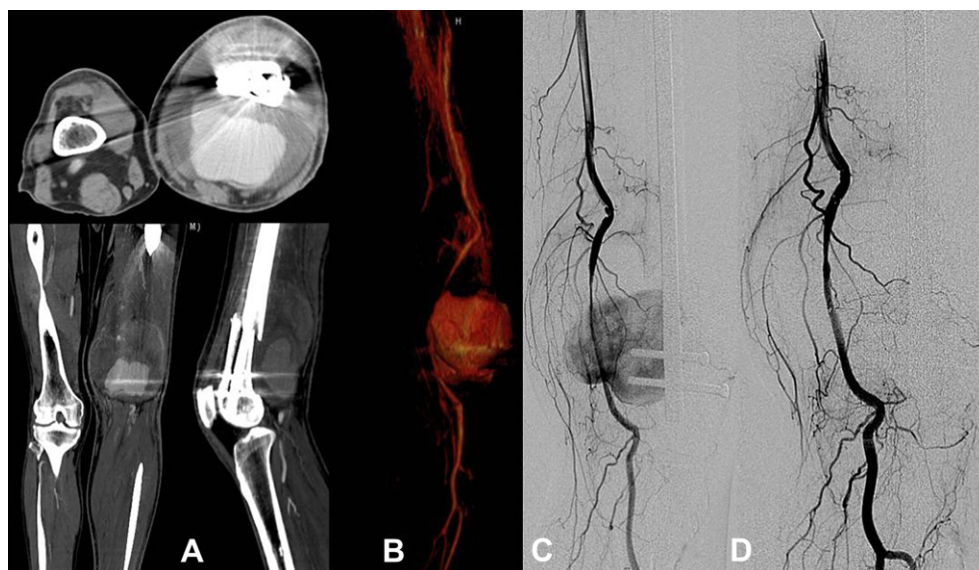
(A) Computed tomographic angiographs showing a huge vascular pouch with contrast pooling anterior to the distal superficial femoral artery; (B) the reconstructed three-dimensional image of vasculature clearly showed that (C) the involved region was compatible with the interventional angiography performed later; (D) extravasation successfully stopped after isolation of the pseudoaneurysm.
